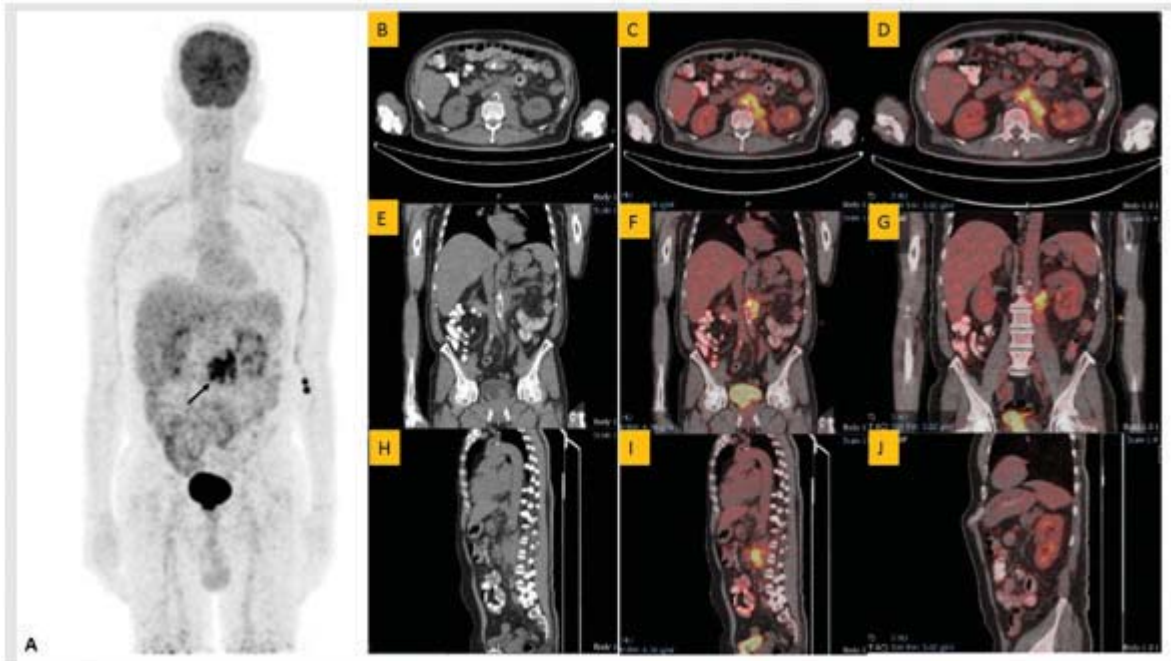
FDG PET/CT non-contrast enhanced Study. A: Maximum Intensity Projection [MIP] image shows enhanced FDG uptake (black arrow) in left paraaortic region. B,C,D (Axial), E,F,G (Coronal) and H,I,J (Sagittal): CT, fused images (at lower and renal hilum level respectively) showing hypermetabolic soft tissue thickening in left paravertebral area extending anteriorly to encase abdominal aorta without involvement of right ureter (absence of right hydronephrosis) or inferior vena cava.
